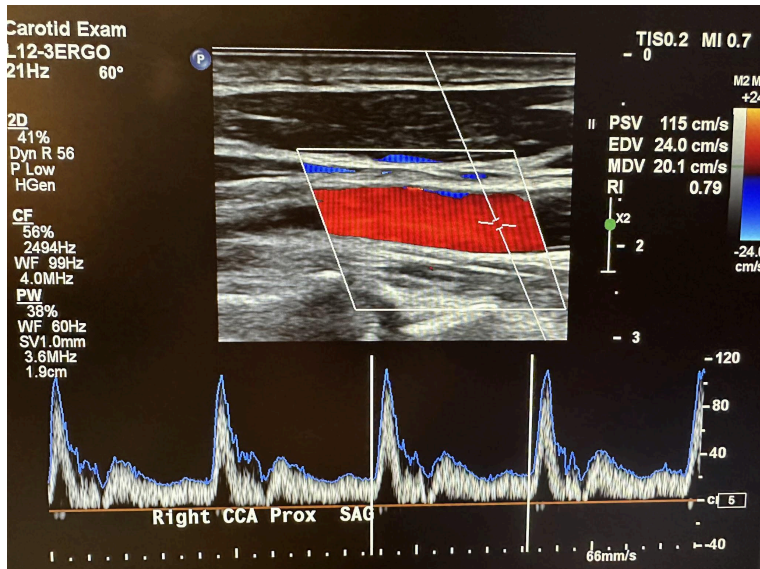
Ultrasound image of the right common carotid artery and the corresponding Doppler waveform.
